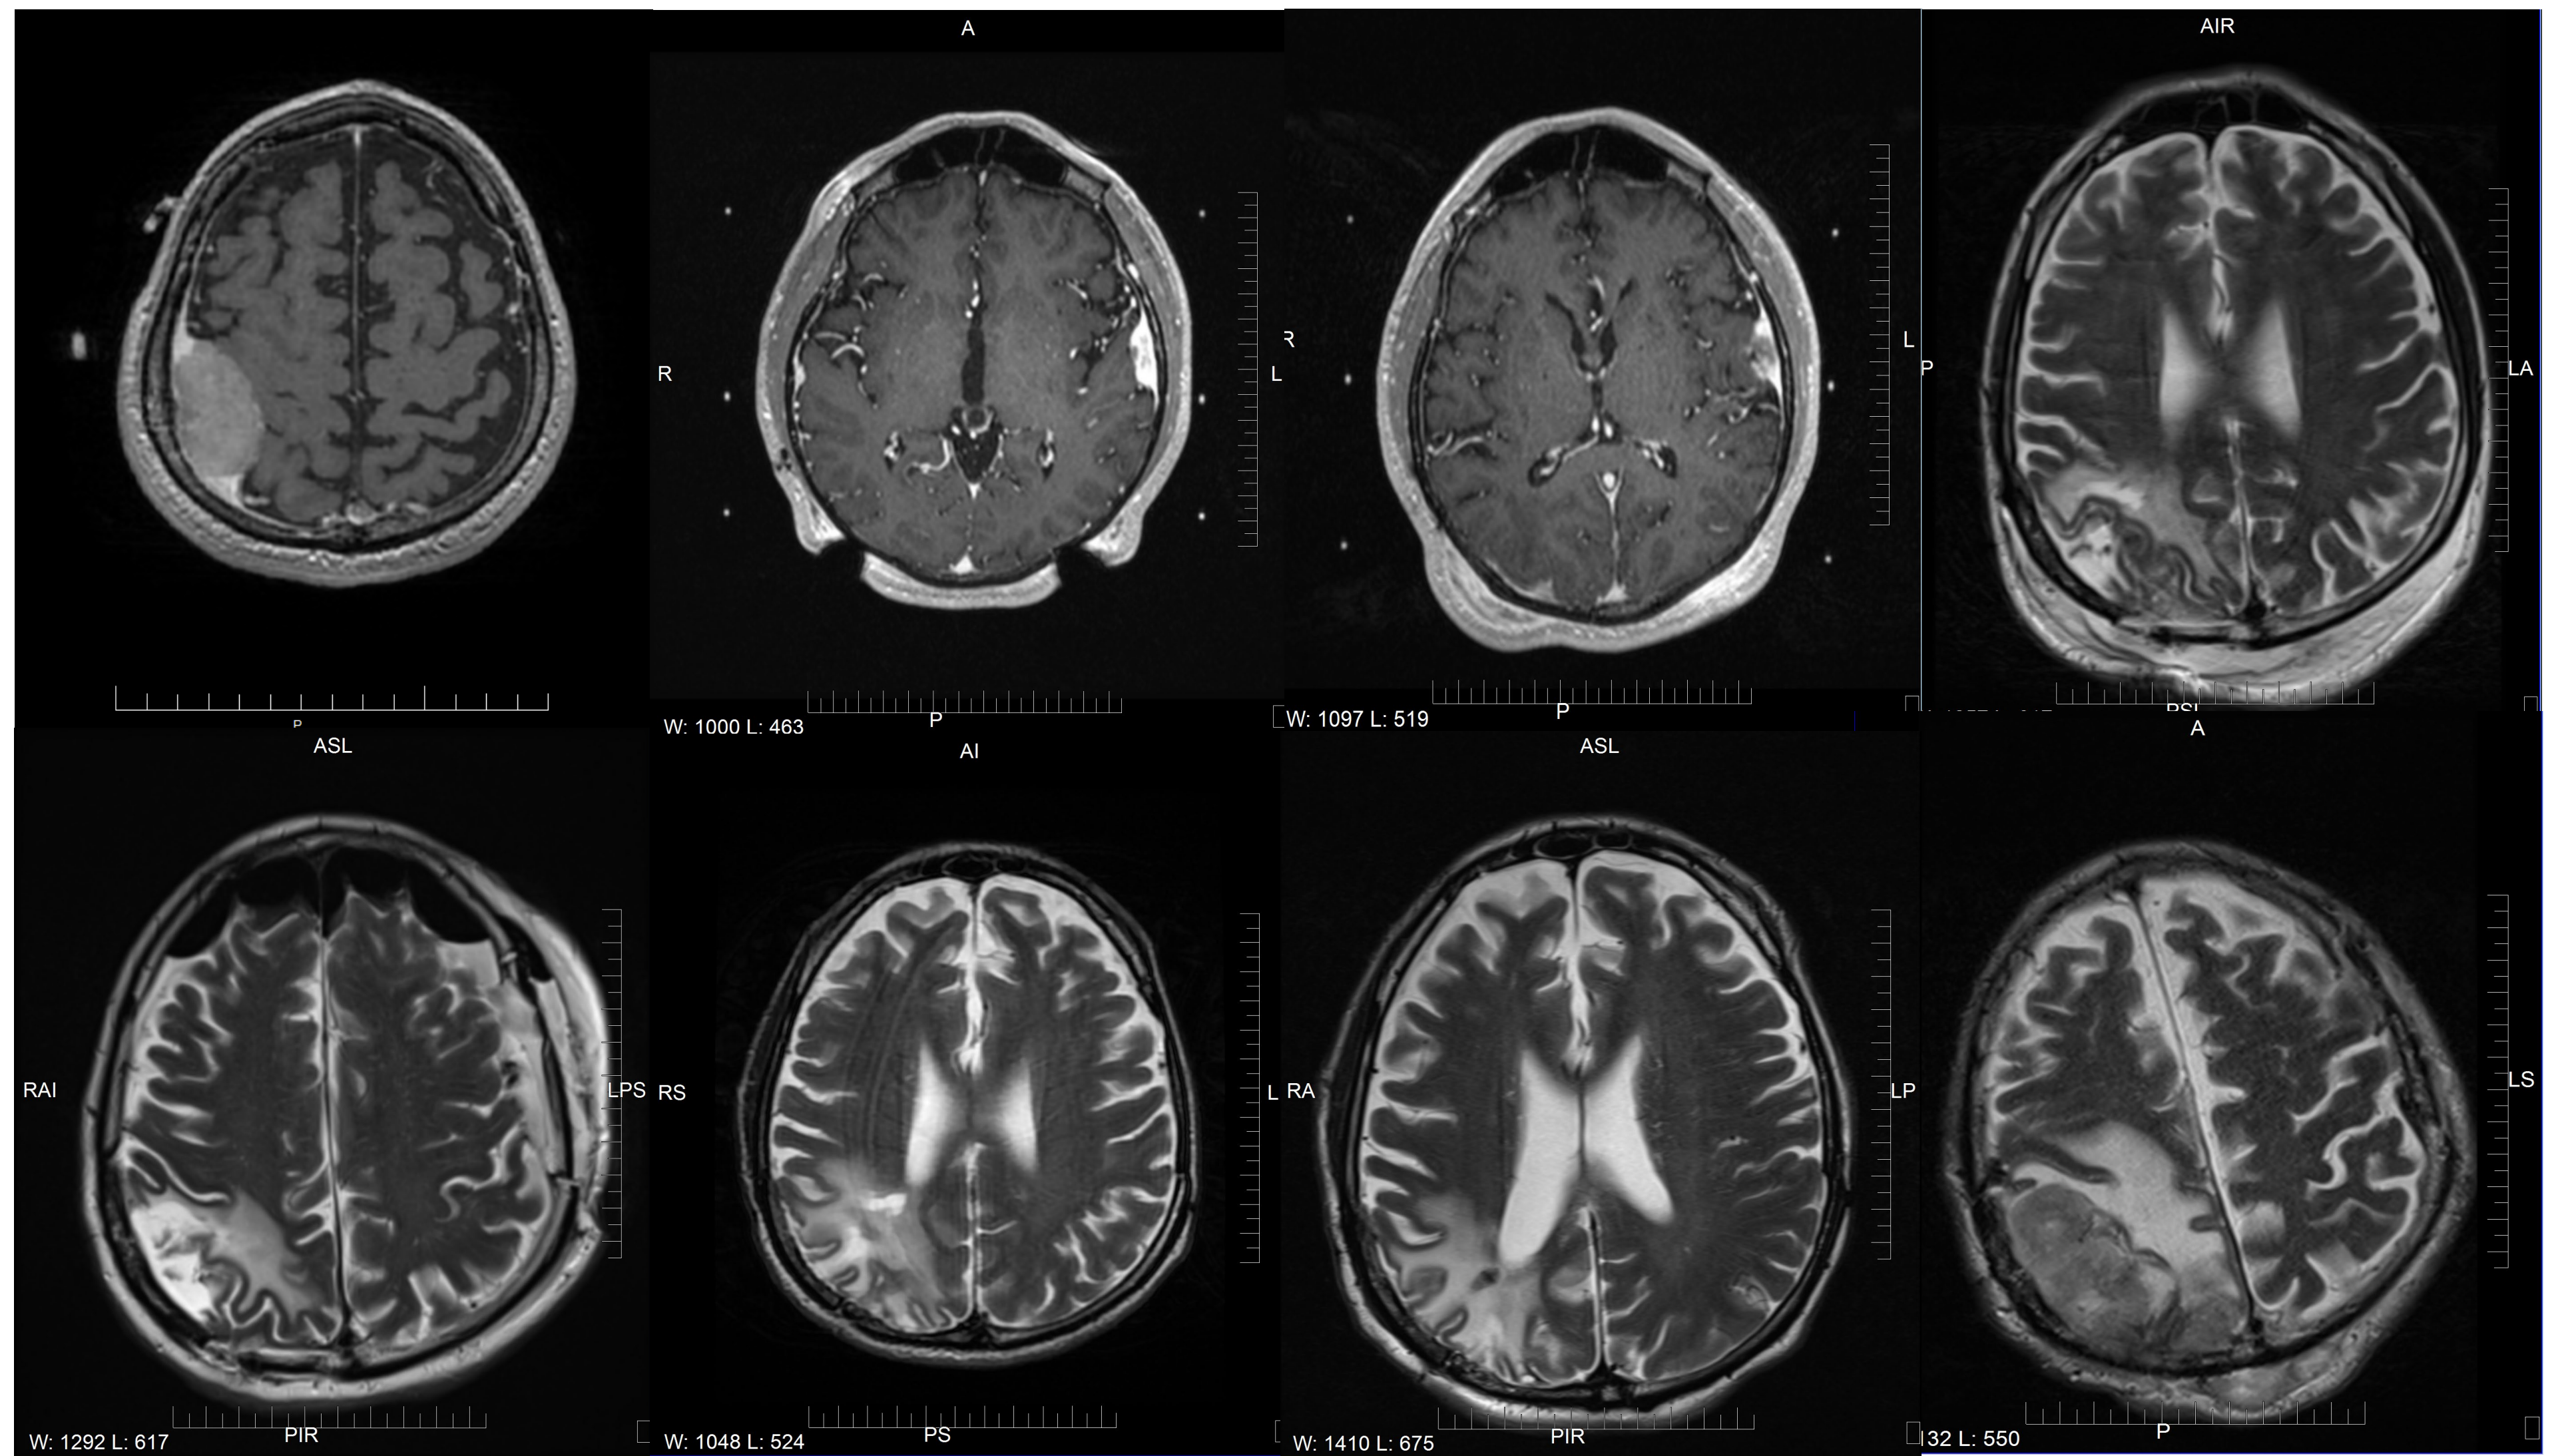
(top left to right: 2015, 2019, 2020, early 2021, bottom left to right: late 2021, 2022, early 2023, late 2023) MRI scans displaying meningiomas pre/post procedures.
